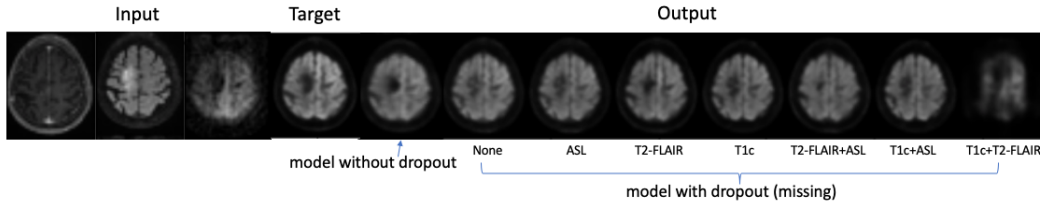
Results with missing contrast. For outputs from model with input dropout, missing: No, ASL, T2-FLAIR, T1c, T2-FLAIR+ASL, T1c+ASL, T1c+T2-FLAIR.
